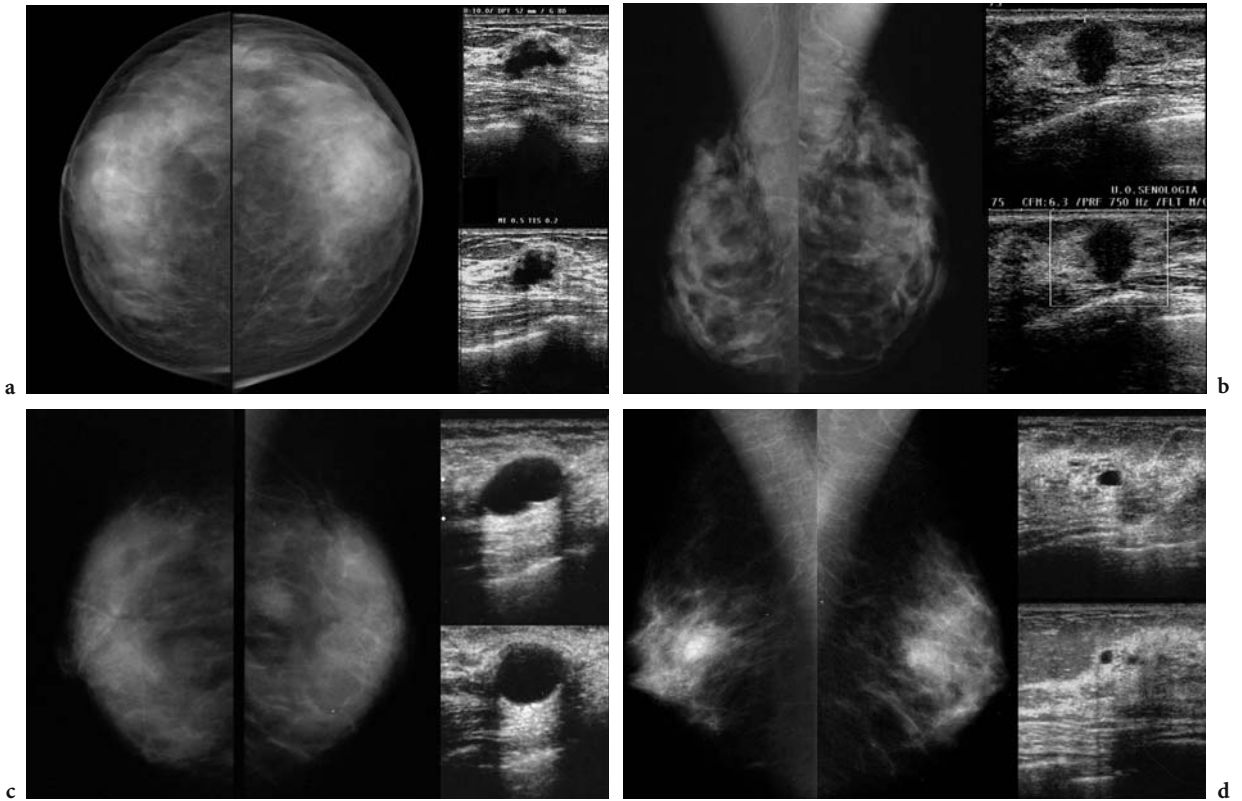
Conventional B-mode ultrasound: findings of benign lesions: a cyst, b lypoma, c fibroadenoma, d intramammary lymph node
